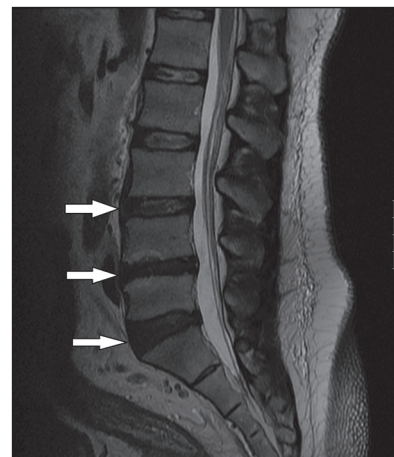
Sagittal T2 weighted MRI image demonstrating degenerated L3-4 through L5-S1 disks in patient 2
